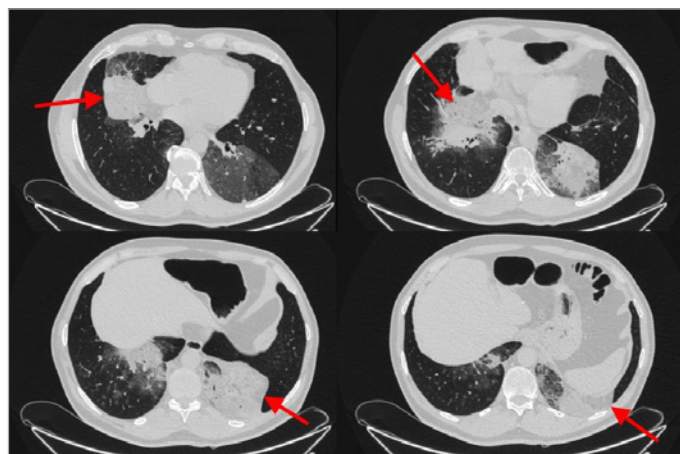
Chest computed tomography. Areas of fat-density in lungs marked by arrows.
